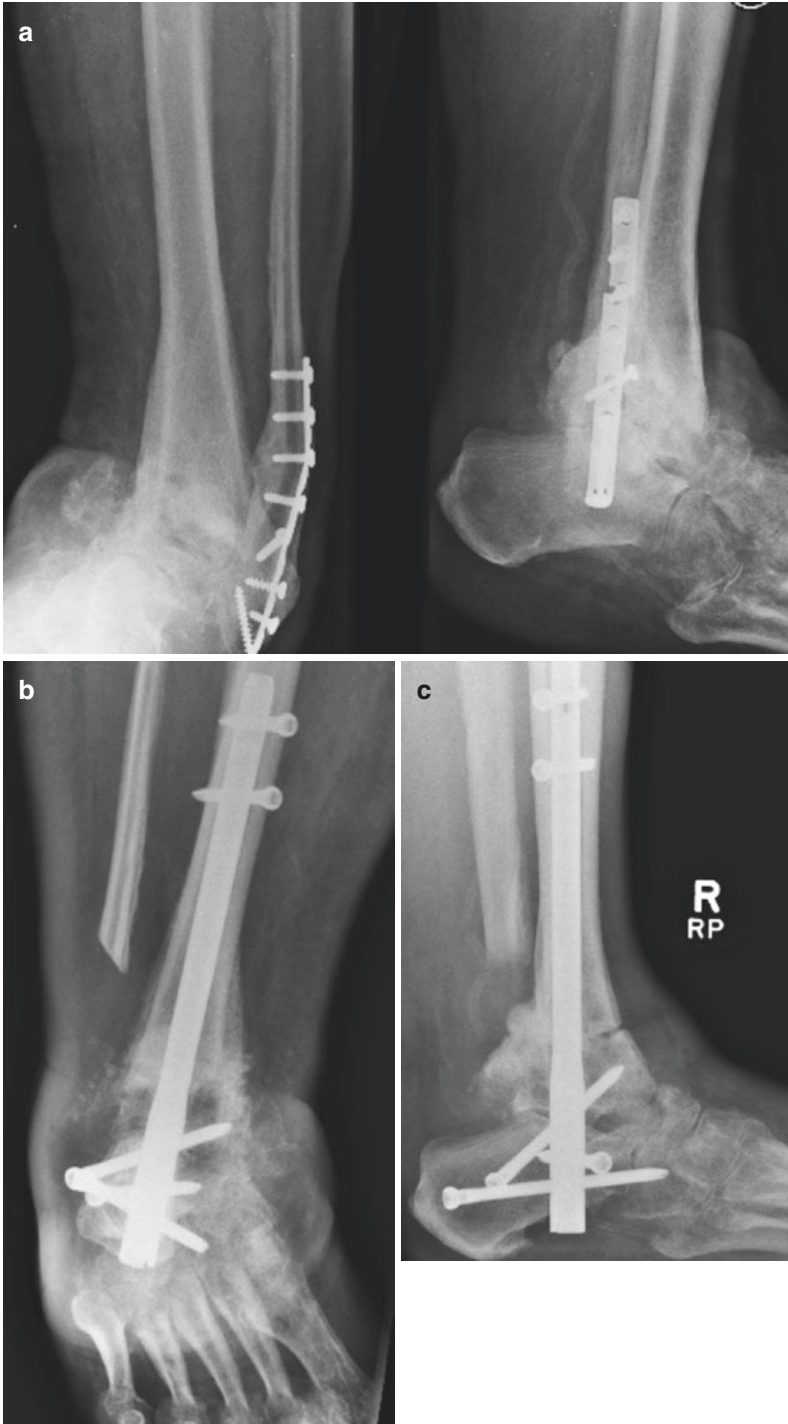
AP and lateral radiographs (a) showing CN of ankle and subtalar joint following an internal fixation of ankle fracture resulting in marked varus deformity and chronic ulceration at the tip of lateral malleolus. Post-operative AP (b) and lateral (c) radiographs following surgical correction
